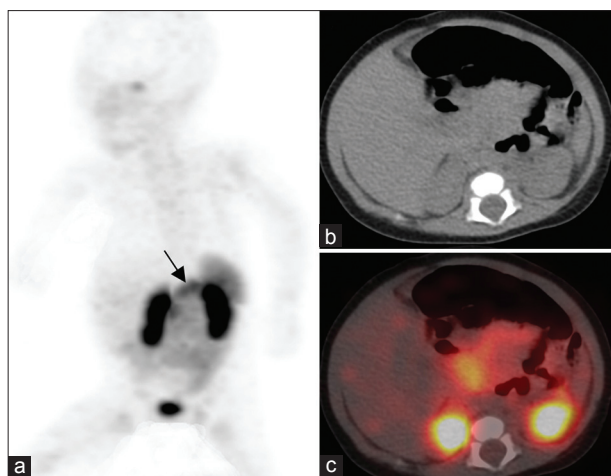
Ga-68 DOTATATE positron emission tomography/computed tomography (CT) (a) Maximum intensity projection (b) transaxial CT (c) transaxial fused images showing diffusely increased tracer uptake in the entire pancreas (arrow) with no abnormal tracer uptake elsewhere in the body, suggestive of a diffuse variant of nesidioblastosis
